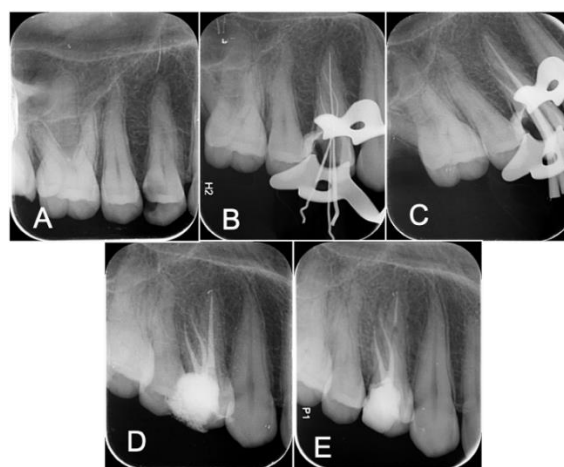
#14: (A) Preoperative periapical radiograph; (B) periapical radiograph with working length; (C) periapical radiograph with master cones; (D) periapical radiograph showing final obturation; (E) periapical radiograph after 6 months follow-up.
